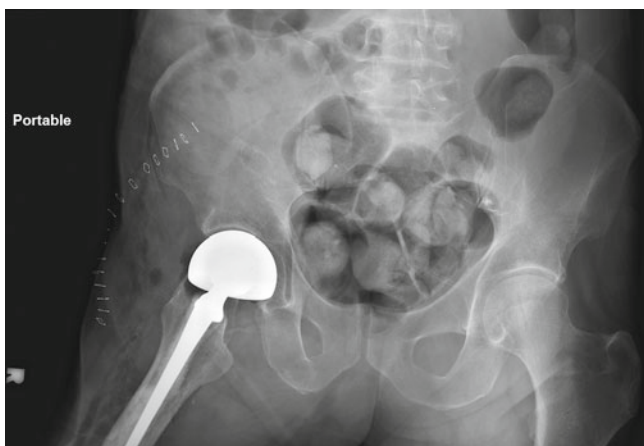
AP pelvis X-ray of a bipolar hemiarthroplasty for treatment of a displaced femoral neck fracture
